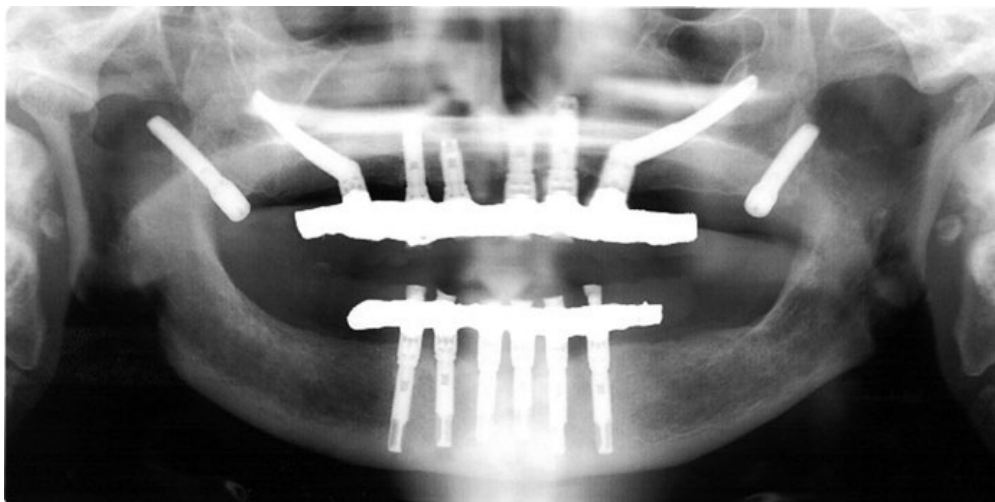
(C) Before treatment: panoramic radiograph demonstrates preexisting prosthesis with failing zygomatic implants.
